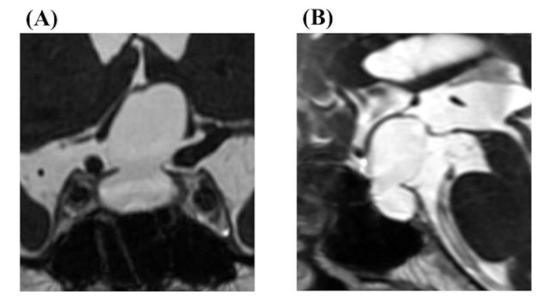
A 62-year-old female manifested with visual function impairment showed a large intrasellar arachnoid cyst extending into the suprasellar cistern. MRI (A; coronal section and B; sagittal section on FIESTA) revealed the arachnoid cyst compressed the optic chiasm remarkably. Her symptom completely diminished after endoscopic cyst removal with endonasal approach.
